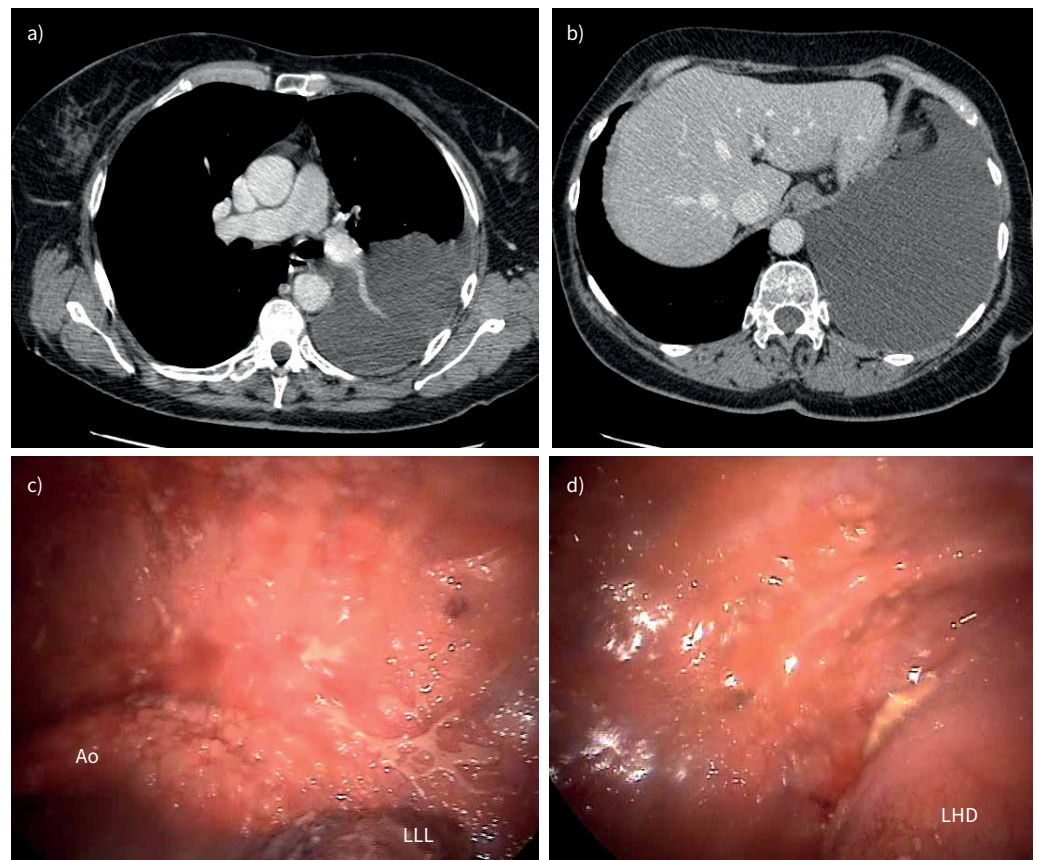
a, b) Axial computed tomography images of a patient with stage I pleural mesothelioma. These demonstrate a large pleural effusion, but no obvious areas of pleural thickening. c, d) Local anaesthetic thoroscopy images recorded in the same patient demonstrating widespread parietal pleural tumour after complete evacuation of the large pleural effusion. Note the descending thoracic aorta (Ao) also covered by tumour, the deflated left lower lobe (LLL) and the left hemidiaphragm (LHD). Reproduced and modified from [58] with permission.
